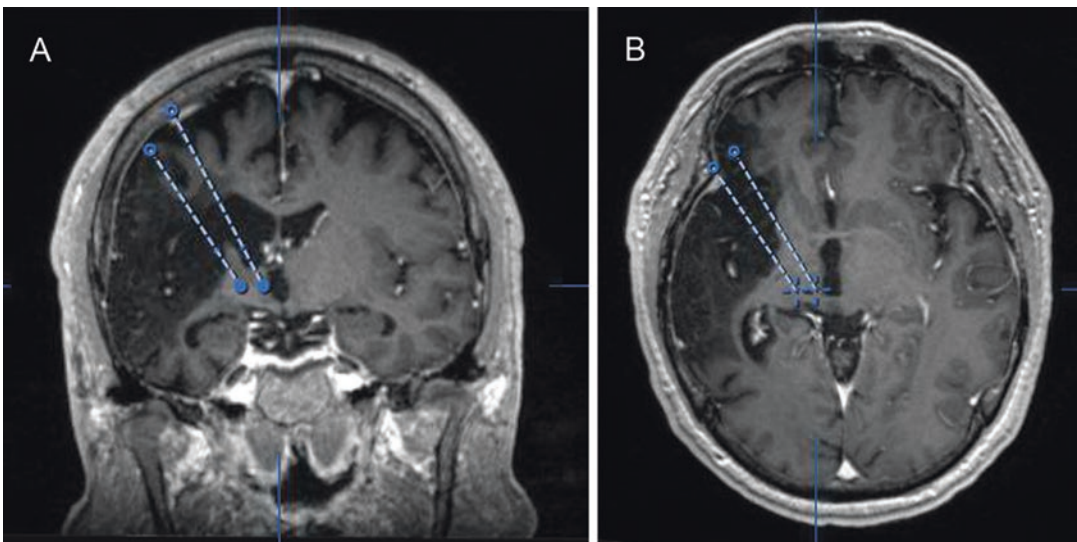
Preoperative planning for deep brain stimulator electrode insertion in a patient with previous left middle cerebral artery infarction and post-stroke central pain. Coronal (a) and axial (b) T1-weighted MRI demonstrates
